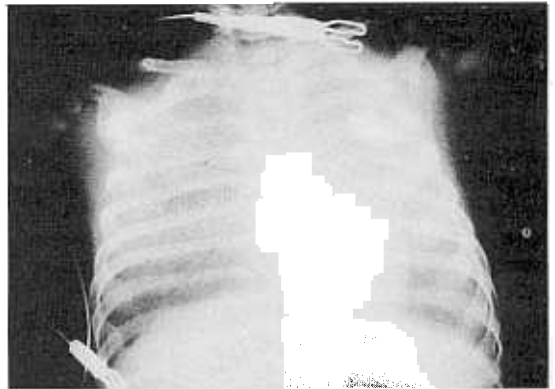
A chest x-ray of this case on admission shows diffuse ground glass appearance on the both lung fields.
